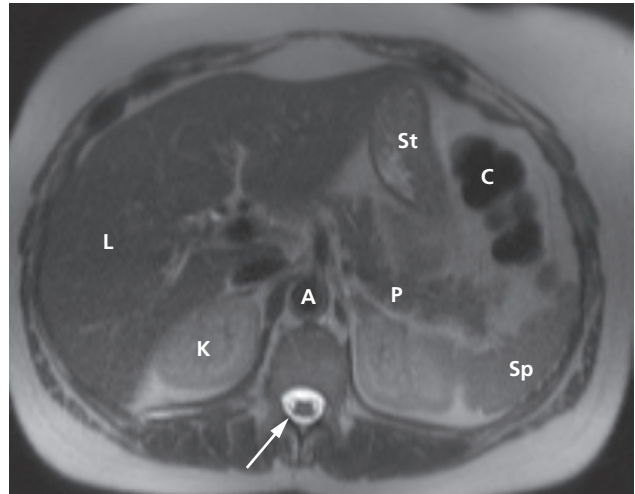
Normal T2-weighted MRI scan of the upper abdomen. The liver parenchyma (L) shows intermediate signal intensity. The cerebral spinal fluid has high signal intensity (arrow). A, aorta; C, splenic flexure of colon; K, kidney; P, pancreas; Sp, spleen; St, stomach.
